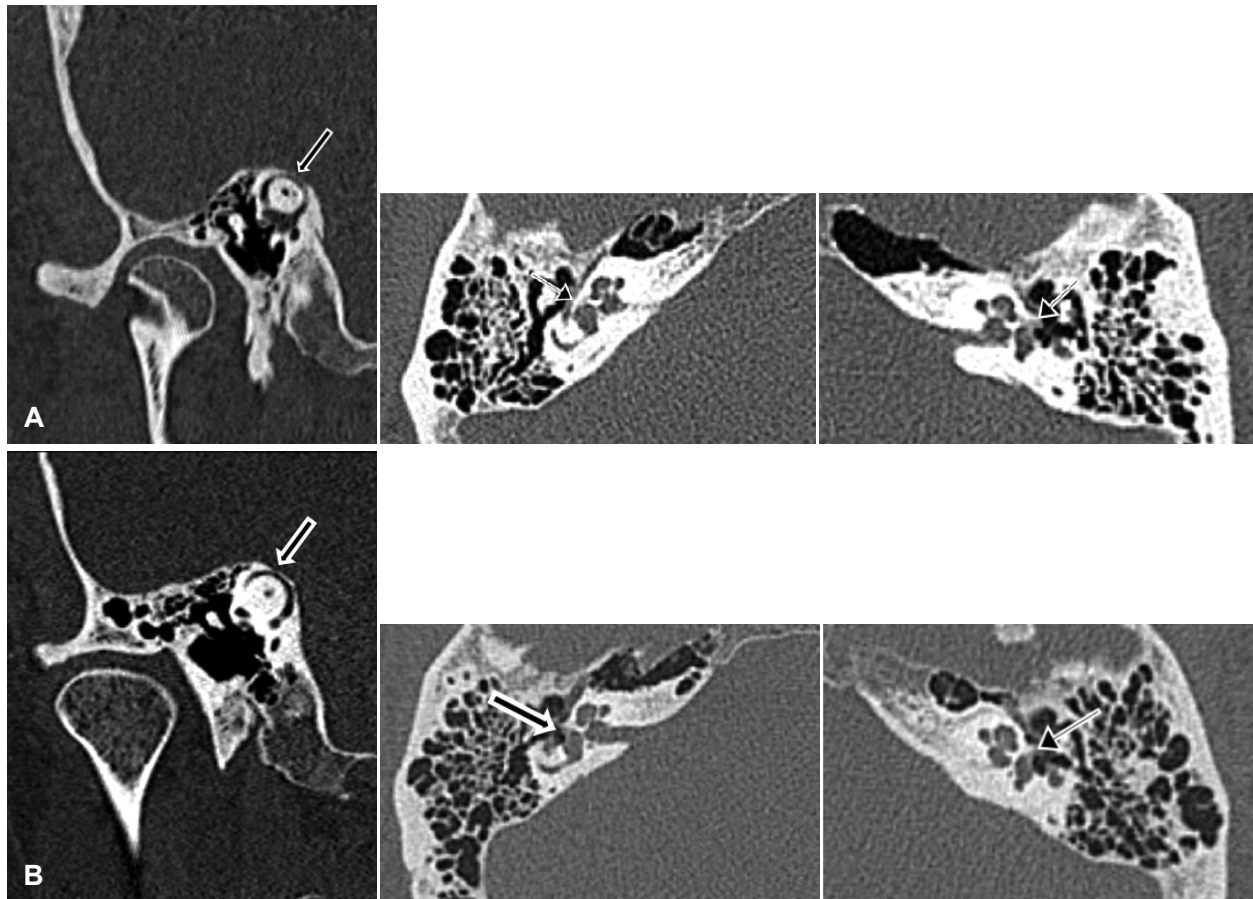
Temporal bone CT images for the twins. A: Twin 1. White arrows point out the near dehiscence of the superior semicircular canal on the right side (Stenvers view) and possible foci of fenestral otosclerosis on the right and left sides (axial views). B: Twin 2. White arrows point out the near dehiscence of the superior semicircular canal on the right side (Stenvers view) and possible foci of fenestral otosclerosis on the right and left sides (axial views).
